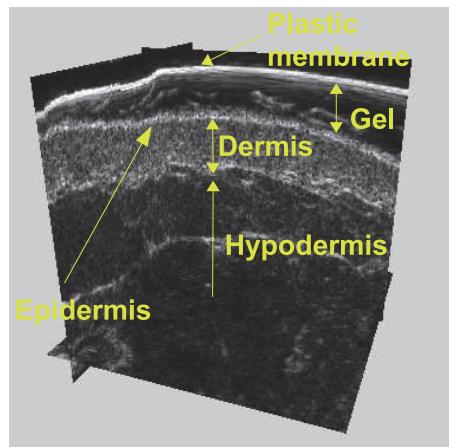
Example of a three-dimensional image of the skin obtained with 20 MHz ultrasound scanner (Atys Medical France)
